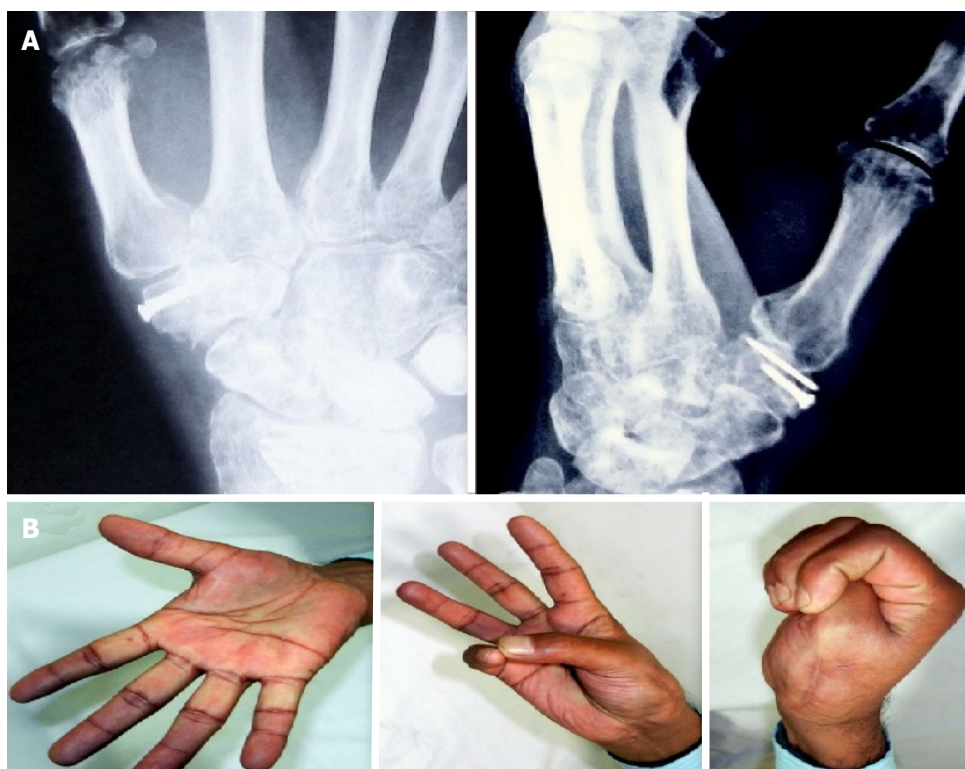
Clinico-radiological follow-up at 6 mo. A: Radiograph at 6 mo follow up showing a healed fracture with maintainance of joint reduction; B: Clinical photograph showing good range of motion.
